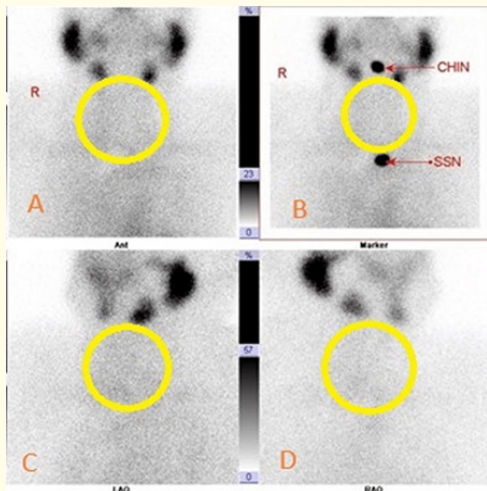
Tc-99m pertechnetate thyroid scintigraphy (thyroid scan) shows almost no activity across all views outlined in yellow in all images A, B, C, D, constant with the previous history of total thyroidectomy. ANT (Anterior), LAO (Left Anterior Oblique), RAO (Right Anterior Oblique), Marker view (with anatomical reference points labeled: CHIN and SSN – suprasternal notch).
